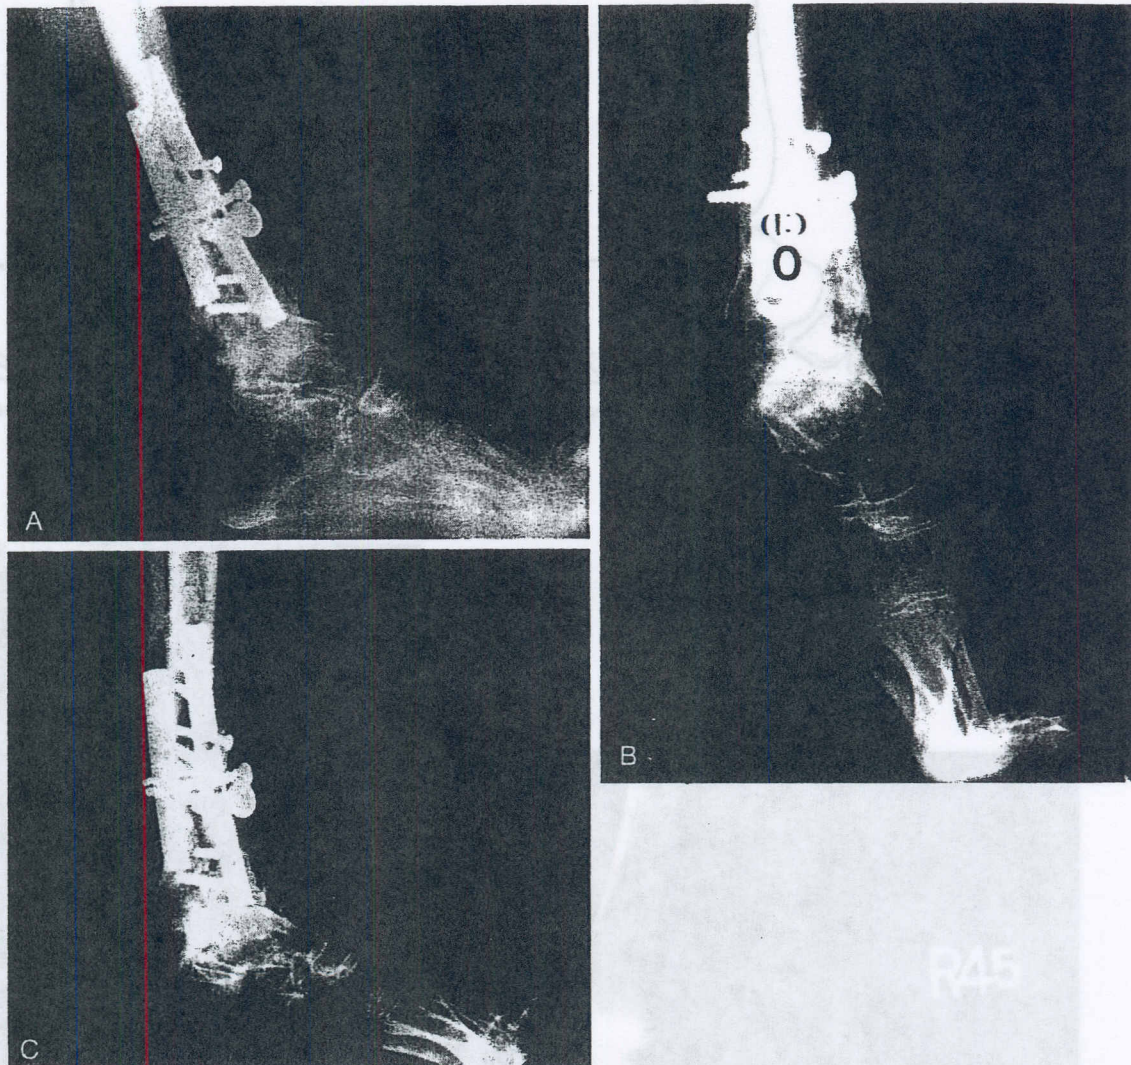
(A), Lateral standing radiograph of a fixed equinus deformity in a woman with juvenile rheumatoid arthritis and a triangular-top talus. (B), The U-osteotomy. (C), The lateral radiograph after correction, demonstrating the acute correction around a U-osteotomy. Note the step in the neck of the talus. (Courtesy of Dror Paley, M.D.)
